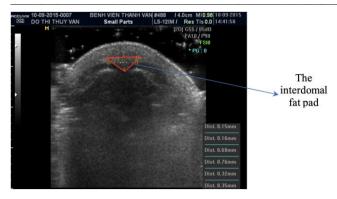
2 The interdomal fat pad on ultrasound
